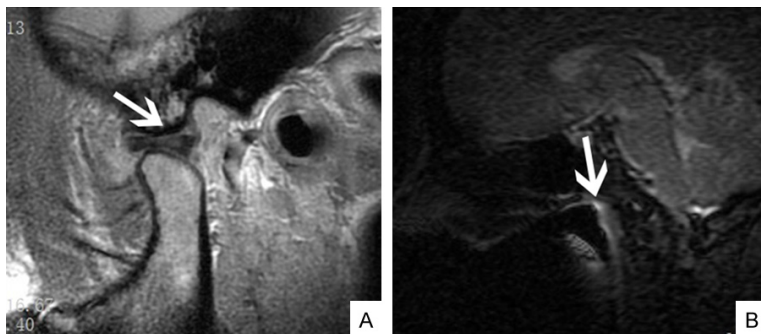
MRI features of temporomandibular disorders. A: Articular disc displacement; B: Joint effusion. MRI, magnetic resonance imaging.
